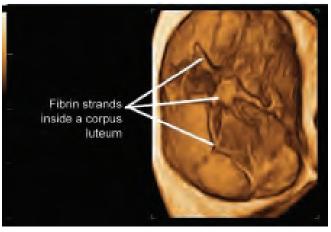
Intracystic fibrin strands within the hemorrhagic cyst are better visualized using surface rendering by three-dimensional ultrasound
